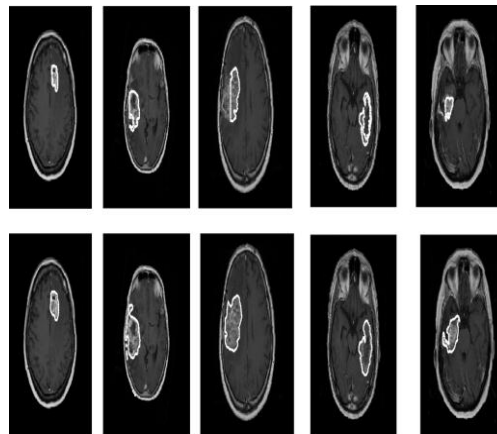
Tumour detection from T1C axial brain MRI slices: top row, results of knowledge based thresholding algorithm; bottom row, results of Chan–Vese algorithm within bounding box found by FBB.
